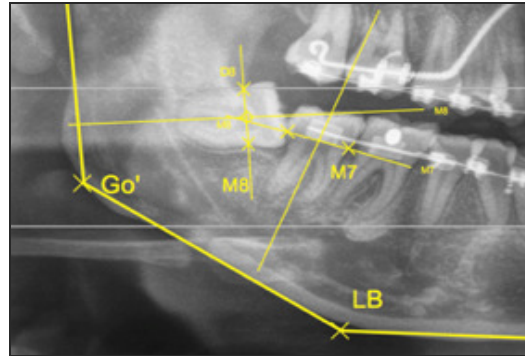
Measurement on panoramic radiograph.
